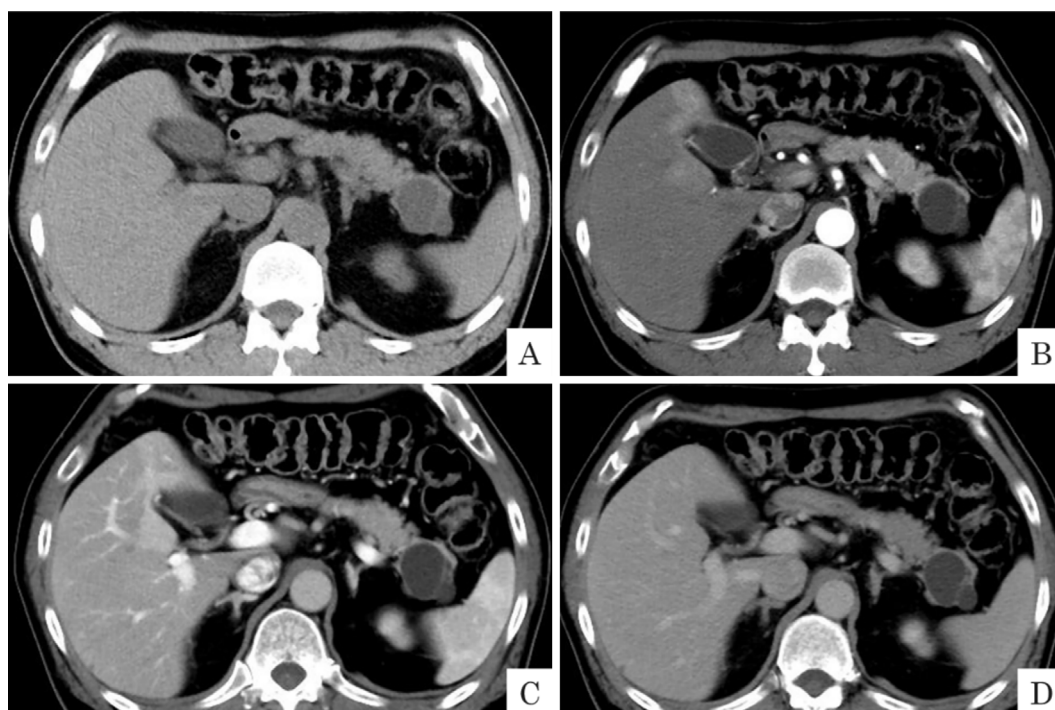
Initial CT images showing a 40-mm multilocular cyst on the pancreatic tail. A) Unenhanced CT image showing a multilocular cyst on the pancreatic tail. B) Arterial-phase CT image showing a multilocular cyst with no enhancement. C, D) Venous-phase CT image showing a multilocular cyst with slight contrast enhancement of the cyst septa.
